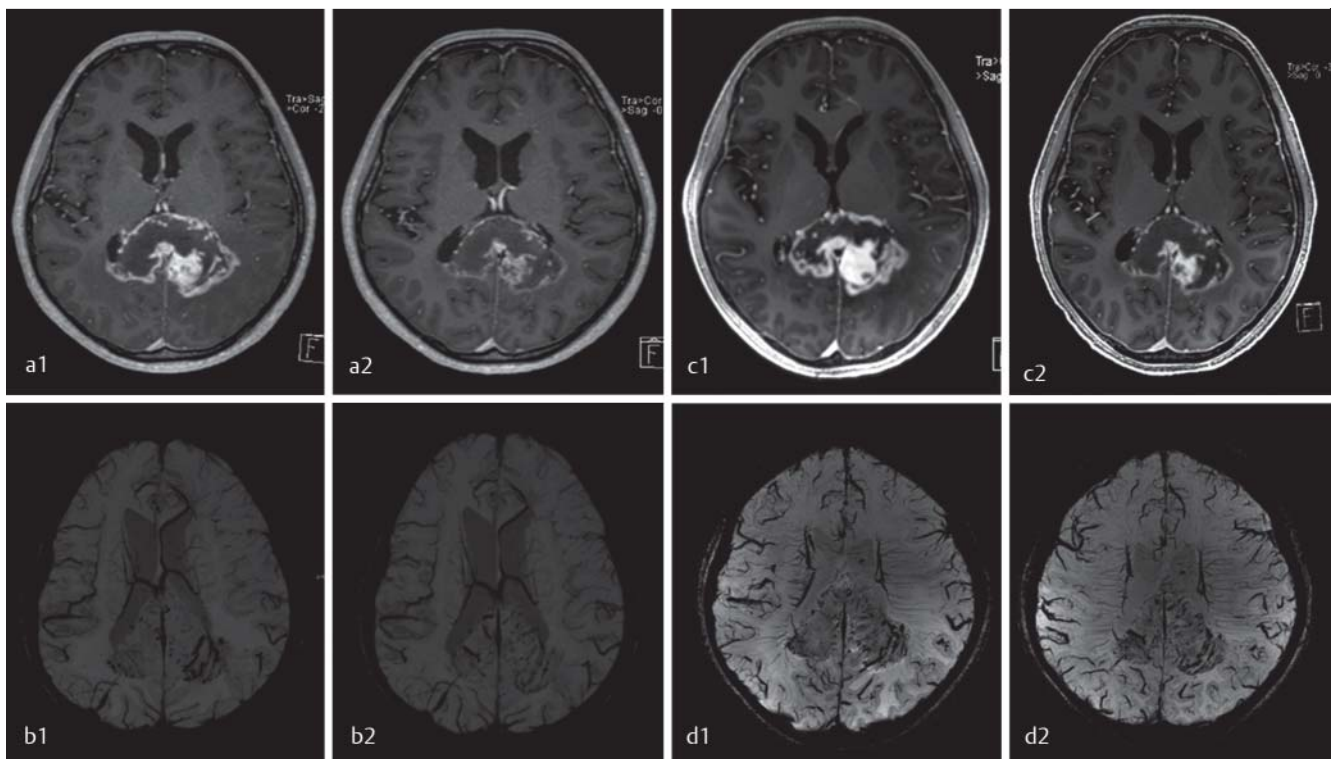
Post-contrast MPRAGE a, c and SWI imaging b, d in a 54-year-old patient with glioblastoma multiforme under anti-angiogenetic chemotherapy. Figures a and b show 3 Tesla imaging, c, d concomitant 7 T images (pretherapeutic and follow-up after the first cycle of chemotherapy as designated in the images). Both field strengths offer excellent assessment of tumor delineation and size reduction in MPRAGE a, c imaging, with superior assessment of tumor microvasculature in 7 T MRI (d1, 2).
